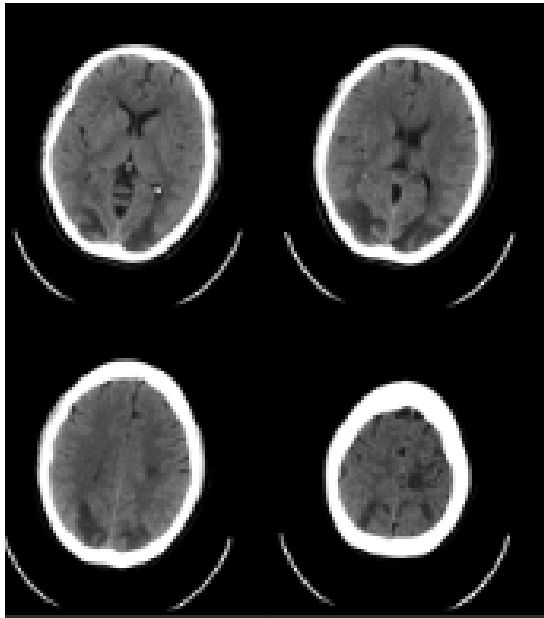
Initial axial brain CT scan
